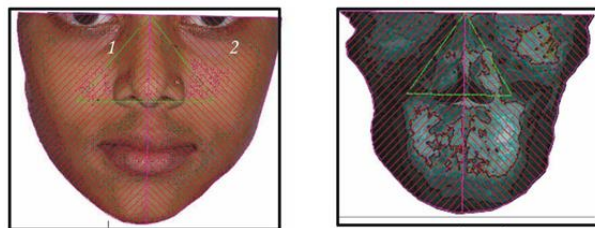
Frontal photograph. Fig 3b: Posteroanterior Radiograph.
